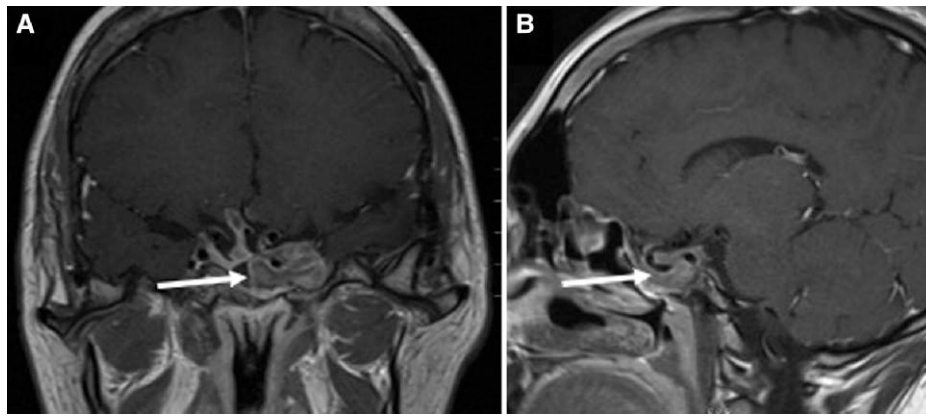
MRI scan of the brain performed with a pituitary protocol, showing (A) coronal and (B) sagittal views, demonstrating the residual tumor present six years after the initial diagnosis (arrows).
